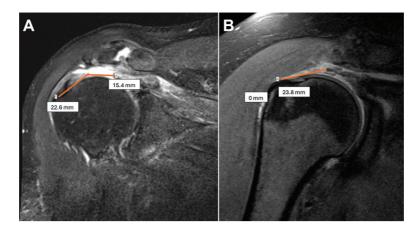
Coronal-oblique magnetic resonance imaging showing the mediolateral tear size (retraction) and remaining stump of the rotator cuff tendon (A) in a transtendinous tear (retraction, 15.4 mm; tendon stump, 22.6 mm) and (B) in a bone avulsion tear (retraction, 23.8 mm; tendon stump, 0 mm).
